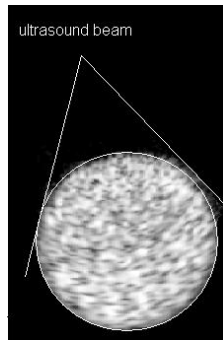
Cross-section of the tube. Ultrasound image after setting the transducer in a transverse position
